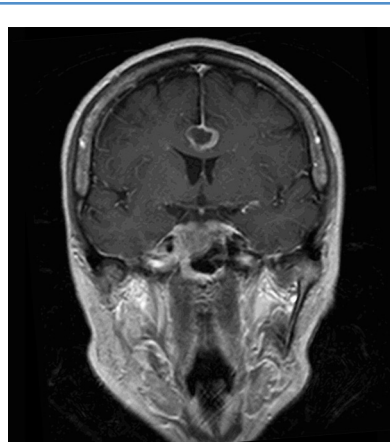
T1-weighted, coronal contrast-enhanced magnetic resonance imaging demonstrating a frontal subfalcine lesion in a 60-year-old woman.
